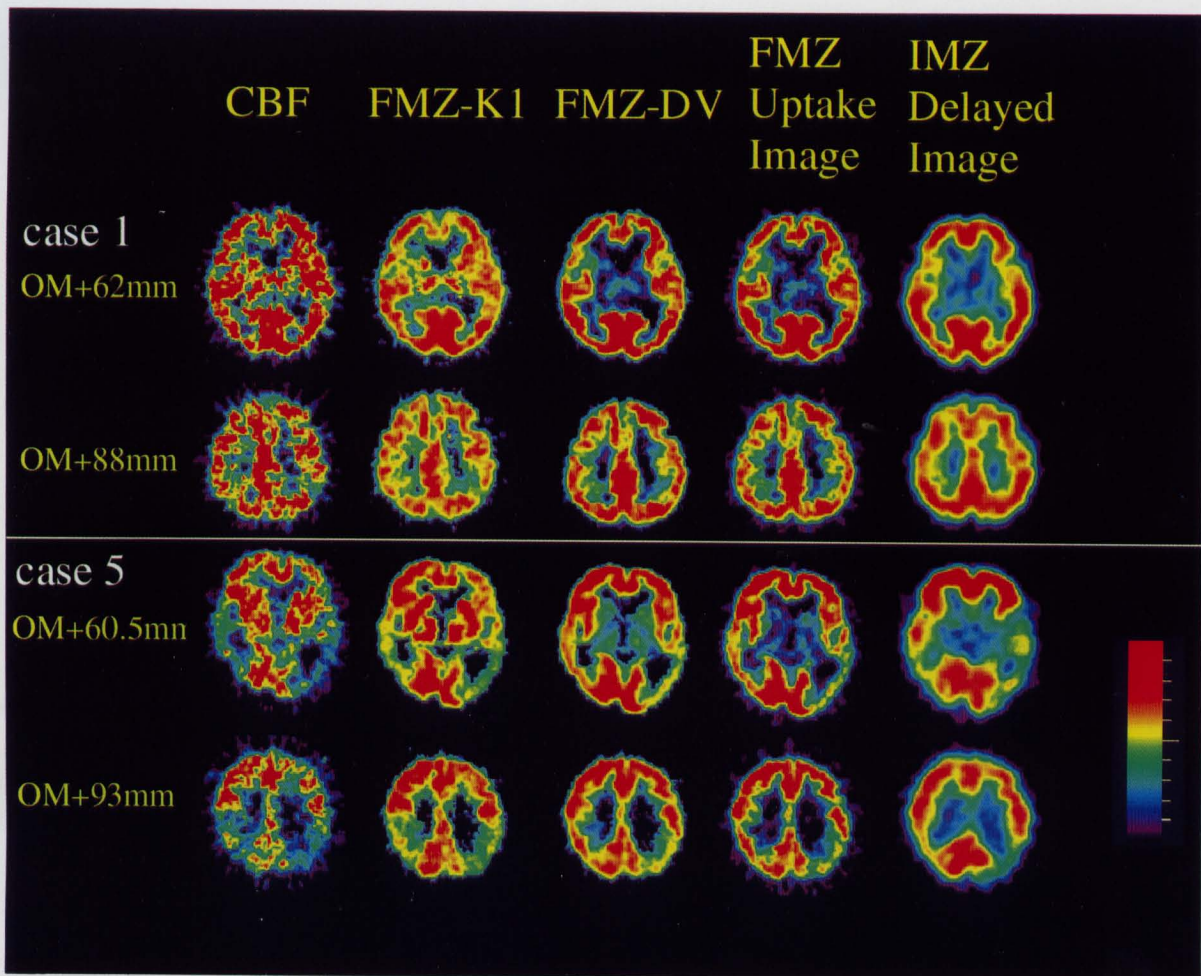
PET images of CBF, FMZ-K₁, FMZ-DV (distribution volume), FMZ-uptake (from 20 to 40 min post injection) and SPECT image of IMZ delayed activity in Alzheimer patient case 1 (mild) and case 5 (moderate). Color scale is arbitrary.
